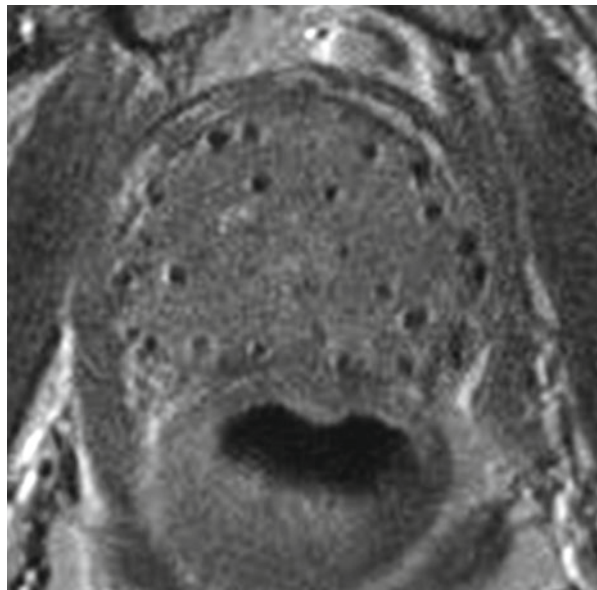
Axial MRI scan showing sources in prostate
